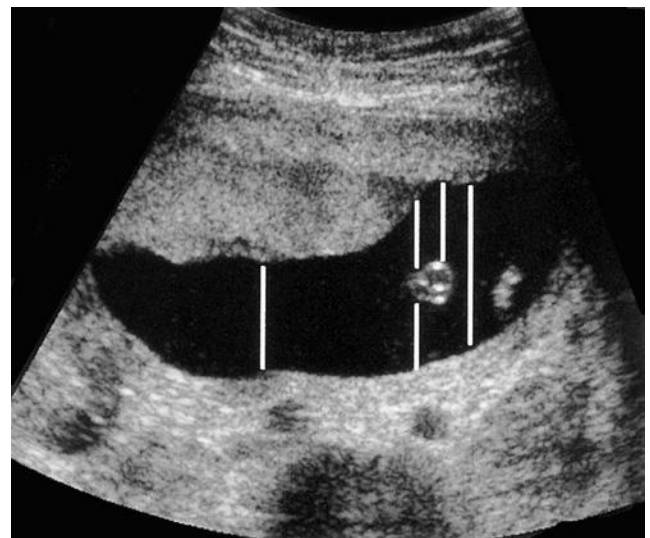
Sonogram of a second trimester pregnancy. Measurements of this amniotic fluid pocket might be made in a variety of locations by different examiners, and some examiners may choose not to use this pocket for measurement.
